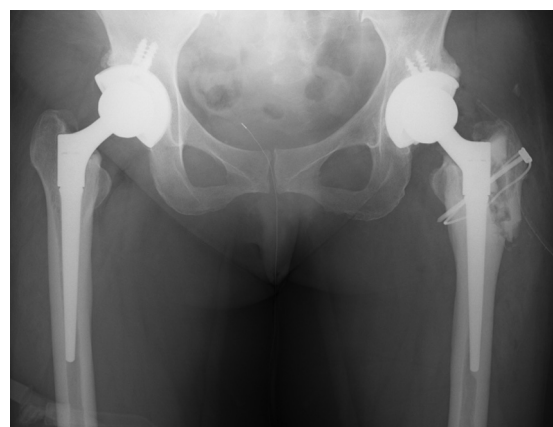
Immediate postoperative radiographic control image after revision of the broken components.
